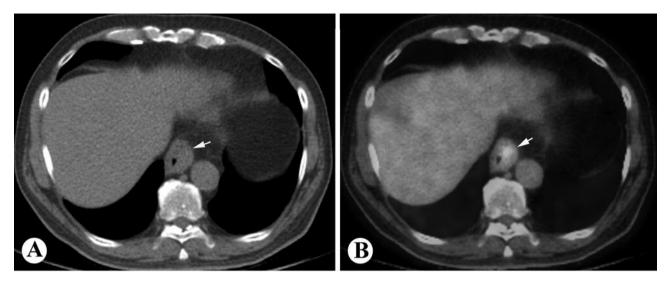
Imaging findings of esophageal carcinoma. A: Computed tomography (CT) scan showing distal esophageal wall thickening (arrow); B: The PET/CT scan similarly showing distal esophageal thickening with increased  $^{18}$ F-Fluorodeoxyglucose (FDG) avidity (arrow).
